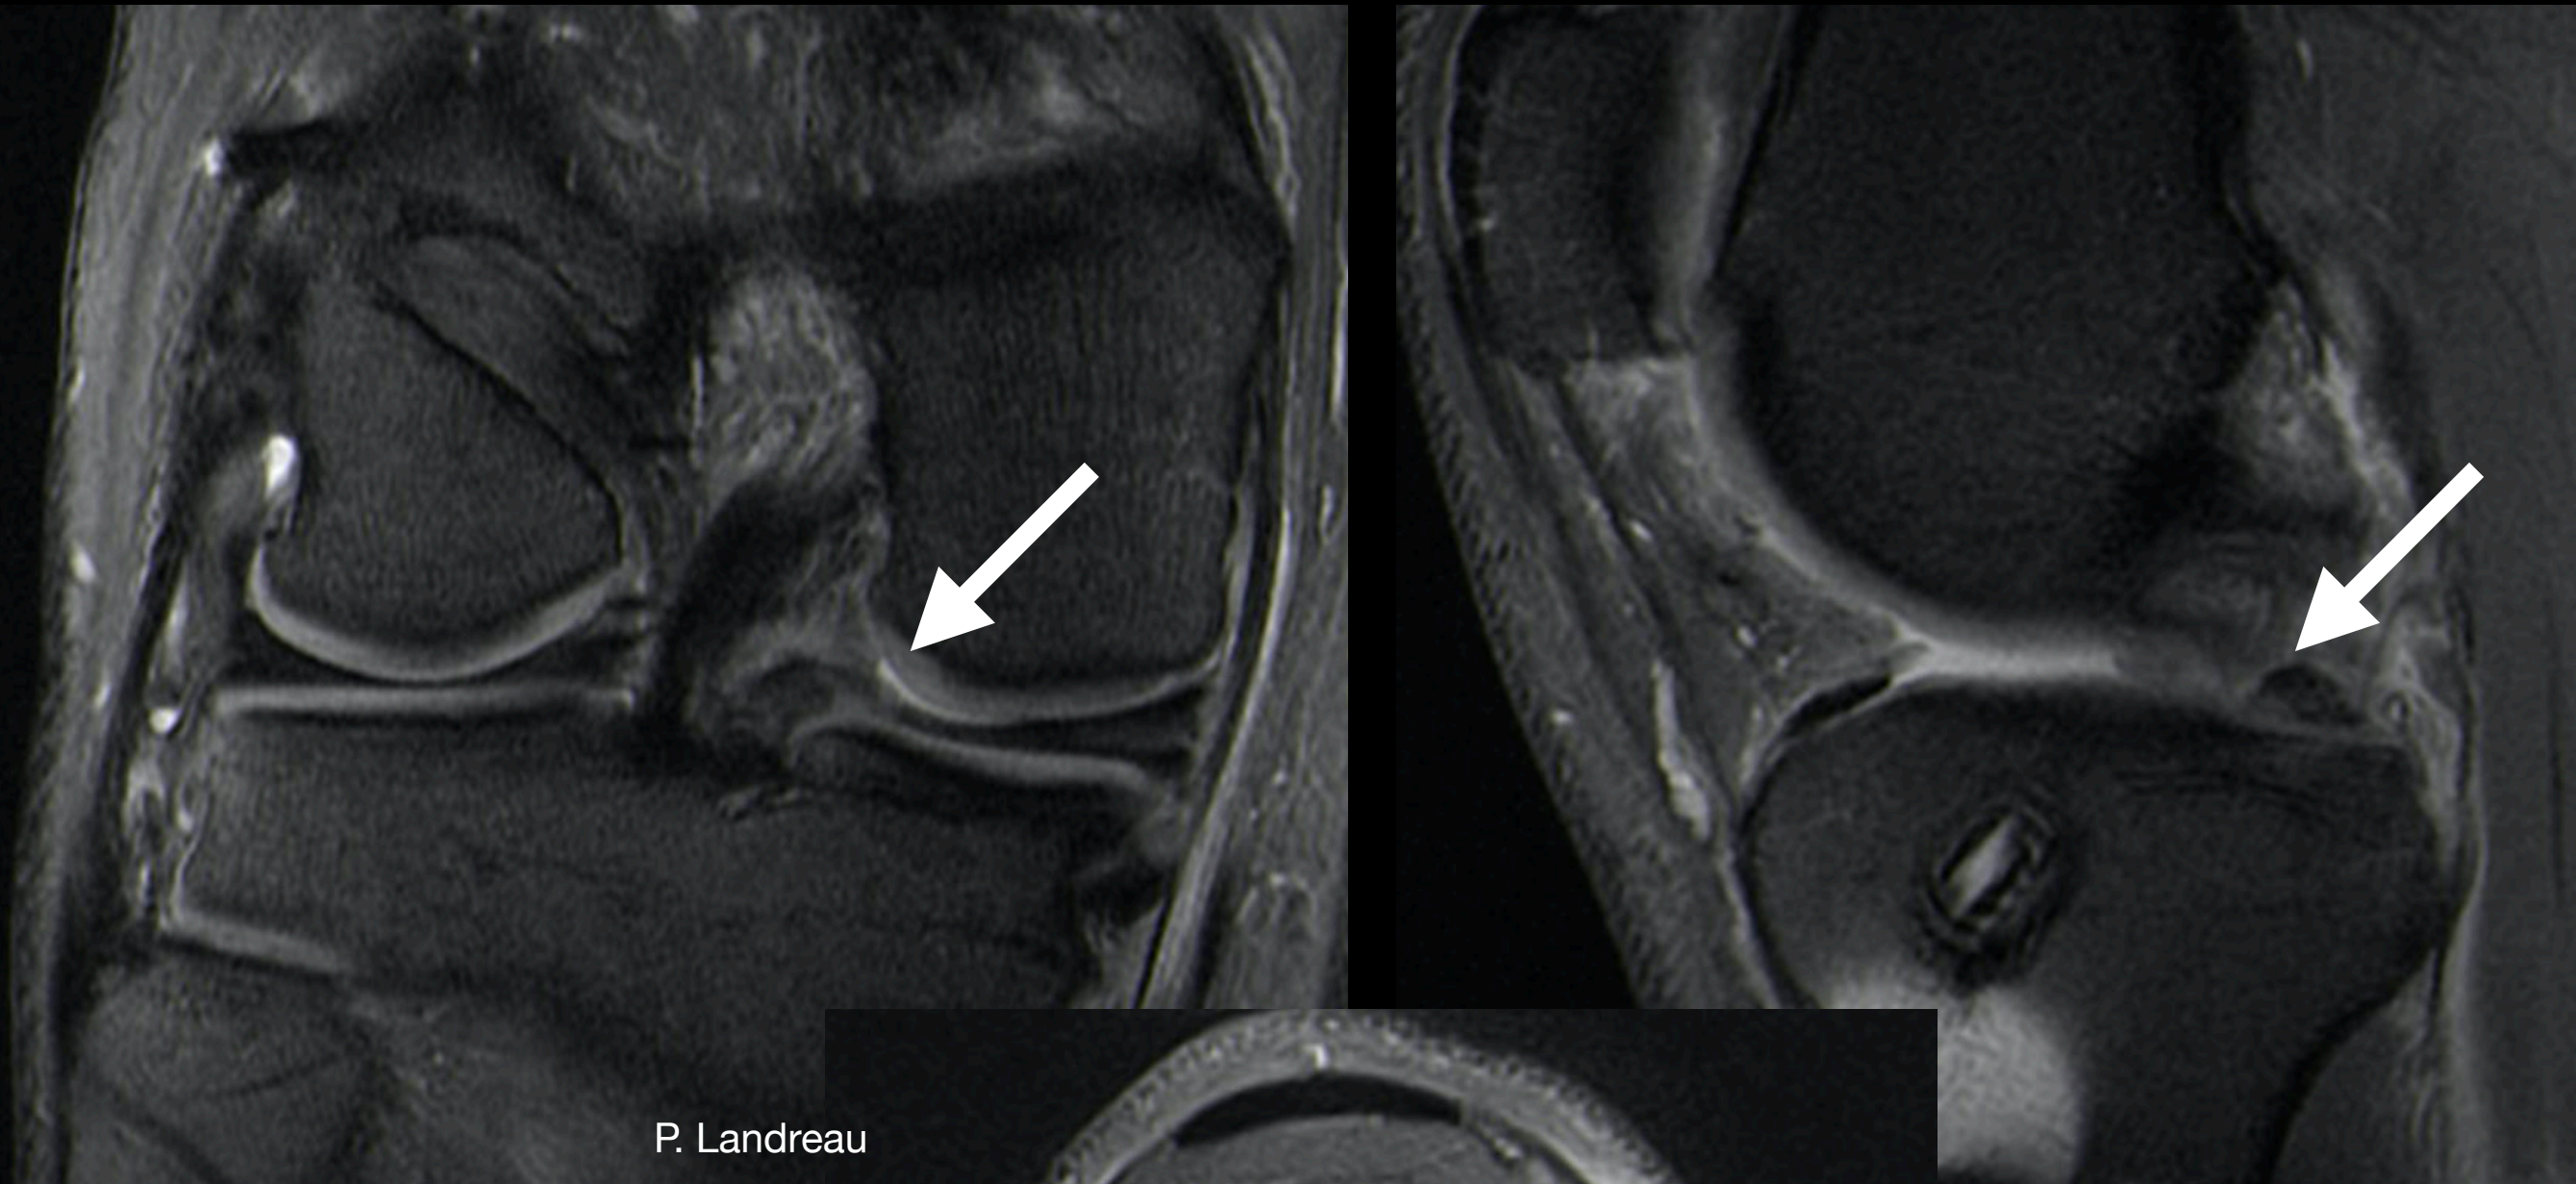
Visualization of meniscal root tears via magnetic resonance imaging. A. Coronal T2-weighted section demonstrating medial meniscal extrusion (arrow) (left knee). B. Axial image demonstrating high signal in region of meniscus root and posterior horn with a radial root tear (arrow) (right knee). C. Sagittal image demonstrating ghost sign (arrow) (right knee). Reprinted with permission from Bhatia et al. (2014).
